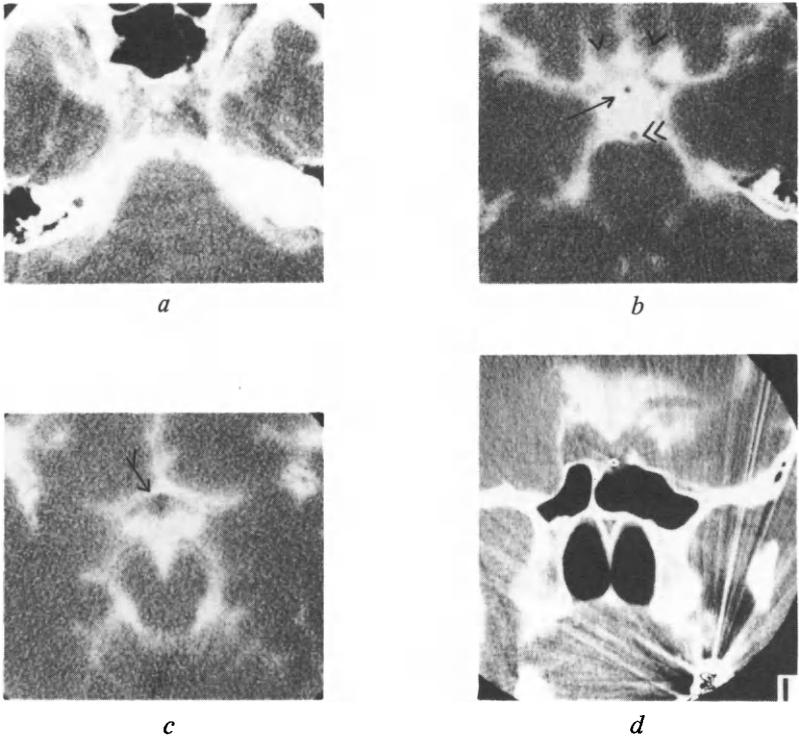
Pituitary adenoma: CT with intrathecal metrizamide. Previously a pituitary adenoma had been treated by yttrium implantation. No radiological evidence of a recurrence. Axial sections (*a*) through the pituitary fossa – contrast medium from the cisterns enters the upper part of the sella; (*b*) through the lower part of the supra-sellar cisterns – optic nerves (v) joined by chiasm in U-shaped image, pituitary stalk (→) and basilar artery (↗); (*c*) just above (*b*) optic chiasm (↔↔) and tracts forming boomerang-shaped image; (*d*) coronal section. There is a surgical defect in the sellar floor below the metallic implant. The normal inferior convexity of the upper border of the pituitary is accentuated opposite the implant, presumably due to contraction of the gland. Note linear artefacts caused by metallic filling in tooth.
